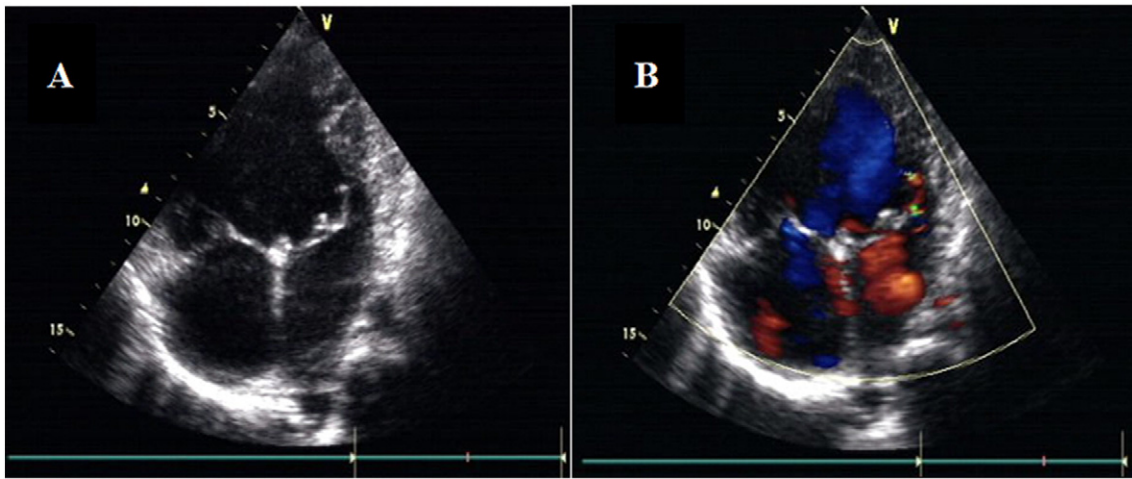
Echocardiography of patient in Case 1. (A) Single ventricle (left type) with double outlets (EF = 58%, apical four-chamber view). (B) Blood flow in early systole (apical four-chamber view).
